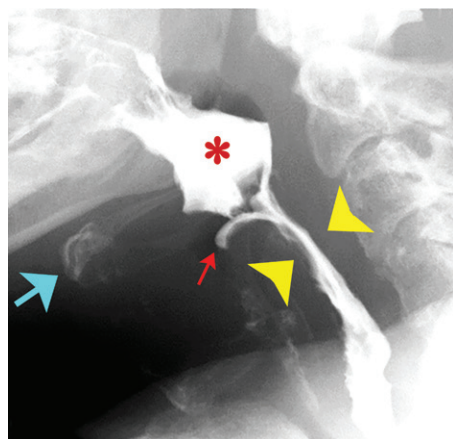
Nonpropulsive pharyngeal contractions in a 66-year-old man. Lateral radiograph of the pharynx during swallowing shows narrowing of the pharyngeal lumen (arrowheads) when the hyoid bone is still elevated (blue arrow). Because of premature pharyngeal closure, some contrast material was trapped in the oropharynx (*) and penetrated the laryngeal vestibule (red arrow).
